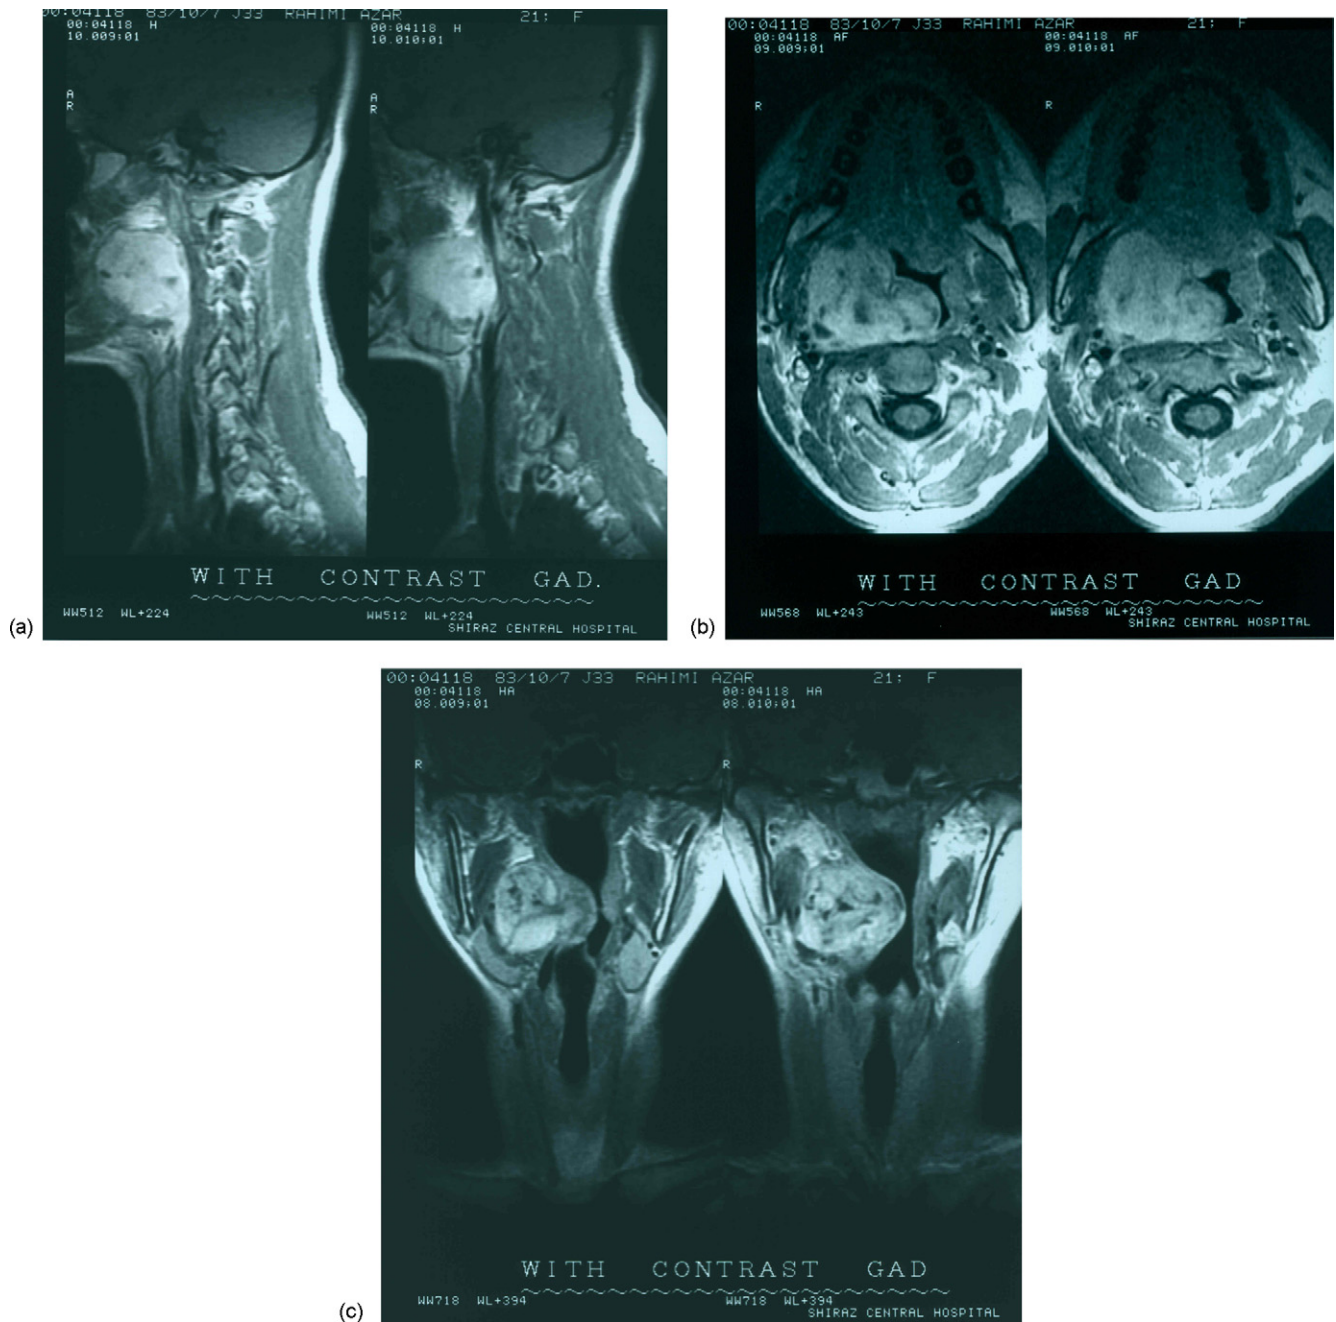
(a–c) Sagittal, axial and coronal contrast-enhanced MR images of the right parapharyngeal synovial sarcoma.
